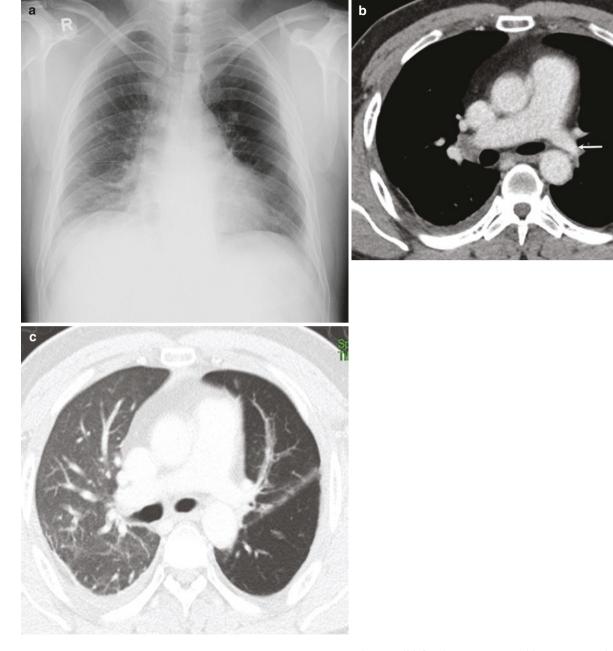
Post-infectious bronchiolitis in a 21-year-old woman. (a) Frontal chest radiograph shows a translucent left hemithorax with a paucity of vascular markings in the left lung. (b, c) Axial CT images
